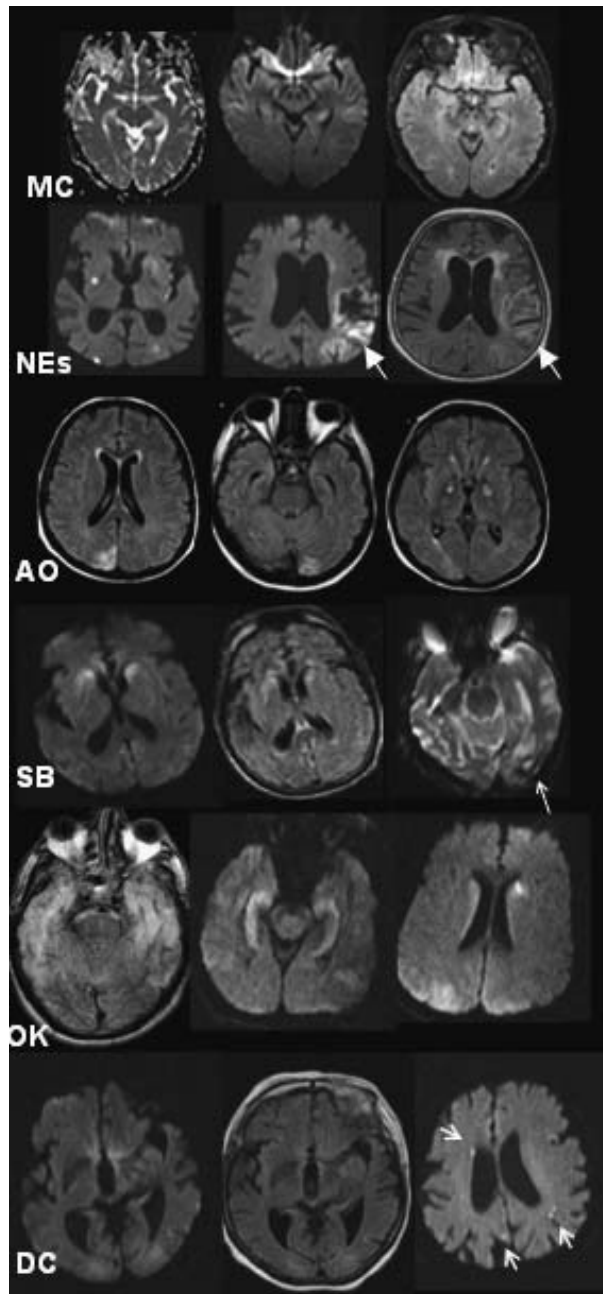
MRI lesions in PRE patients with a good prognosis. Closed arrow shows left middle cerebral artery inferior division infarct, open arrow shows left occipital hemorrhage, small arrows show small embolic lesions. Eye of the tiger appearance is seen at the third row last picture (AO).
